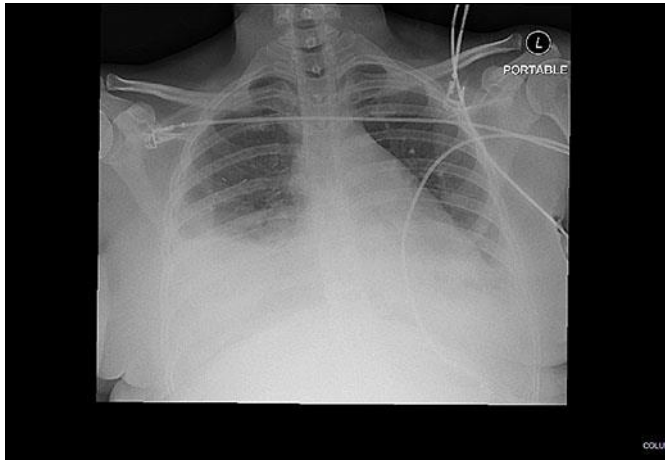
Chest X-ray showing pleural effusion and an obscured costal phrenic angle.
